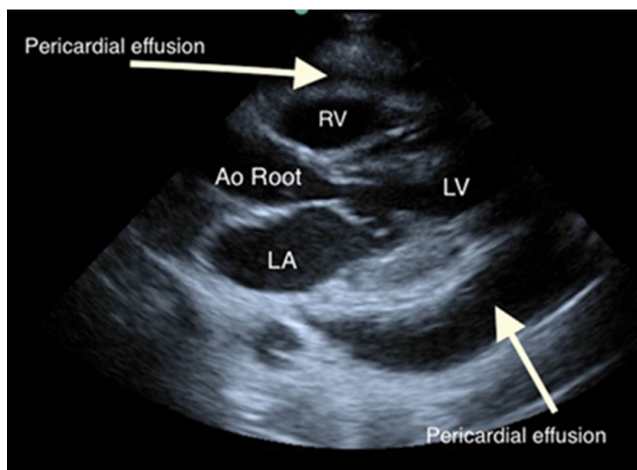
Echocardiogram shows moderate amount of pericardial effusion (white arrows). RV = right ventricle, LV = left ventricle, LA = left atrium, and Ao = aorta.
